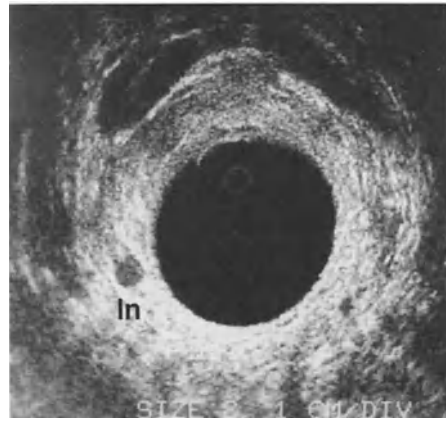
Sonogram of the perirectal area cephalad from a rectal cancer. On left side of sonogram: hyperechoic lymph node (*ln*) of 12 mm diameter surrounded by a hypoechoic circle. *bl*, bladder; *s*, sacrum; *v*, vein
